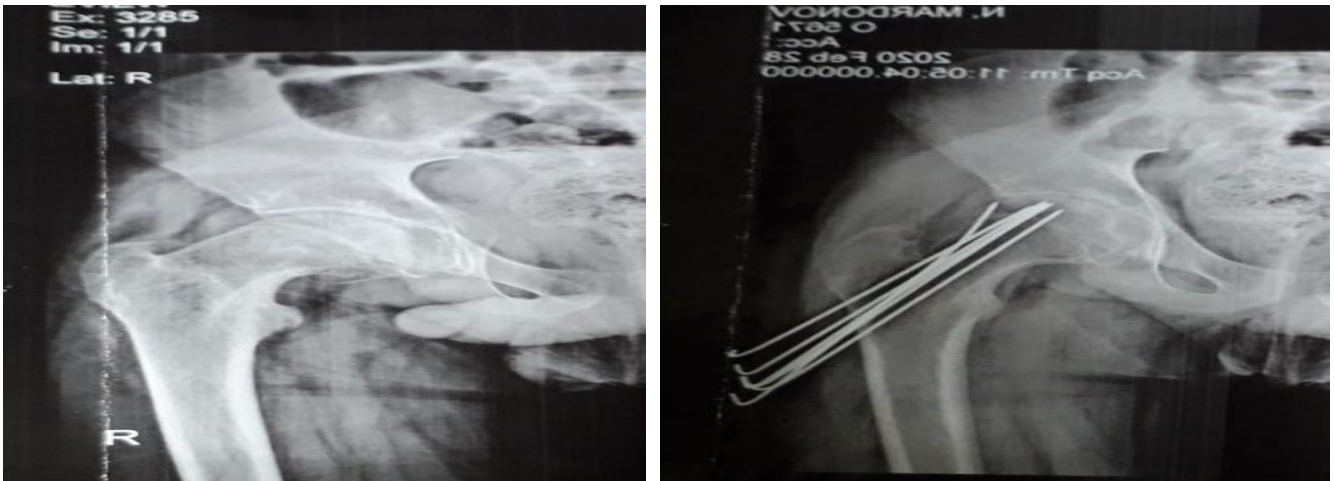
Radiograph of patient K., 10 years old. Diagnosis: EHEC. Before and after percutaneous osteosynthesis surgery.
